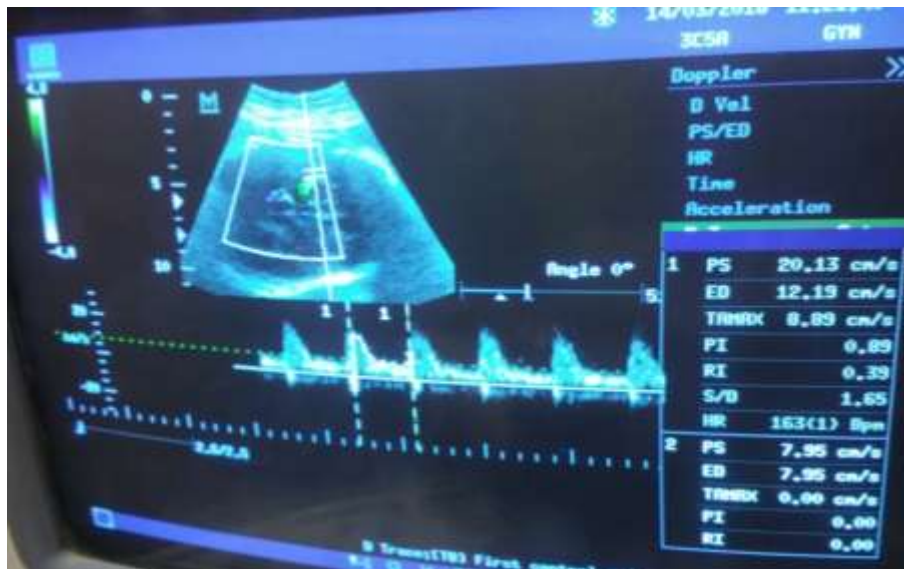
b) shows color Doppler middle cerebral artery waveform at 38
